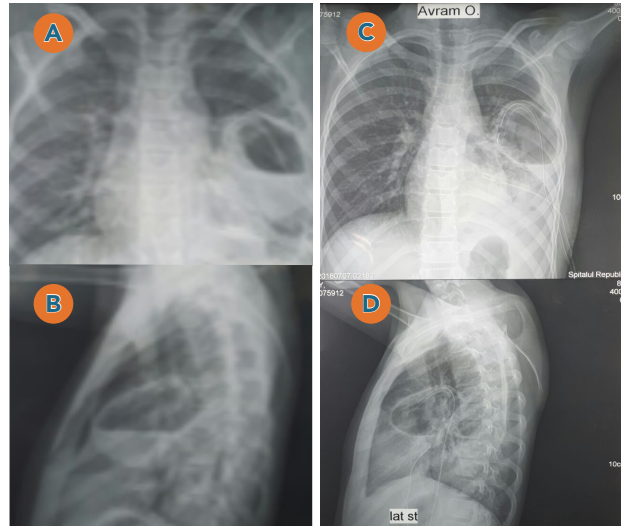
Patient A., 10 years. A – chest X-ray performed on the 3rd postoperative day: the presence of the residual cavity with fluid drained out (A, B), which is maintained on the 38th day after surgery (C, D)
